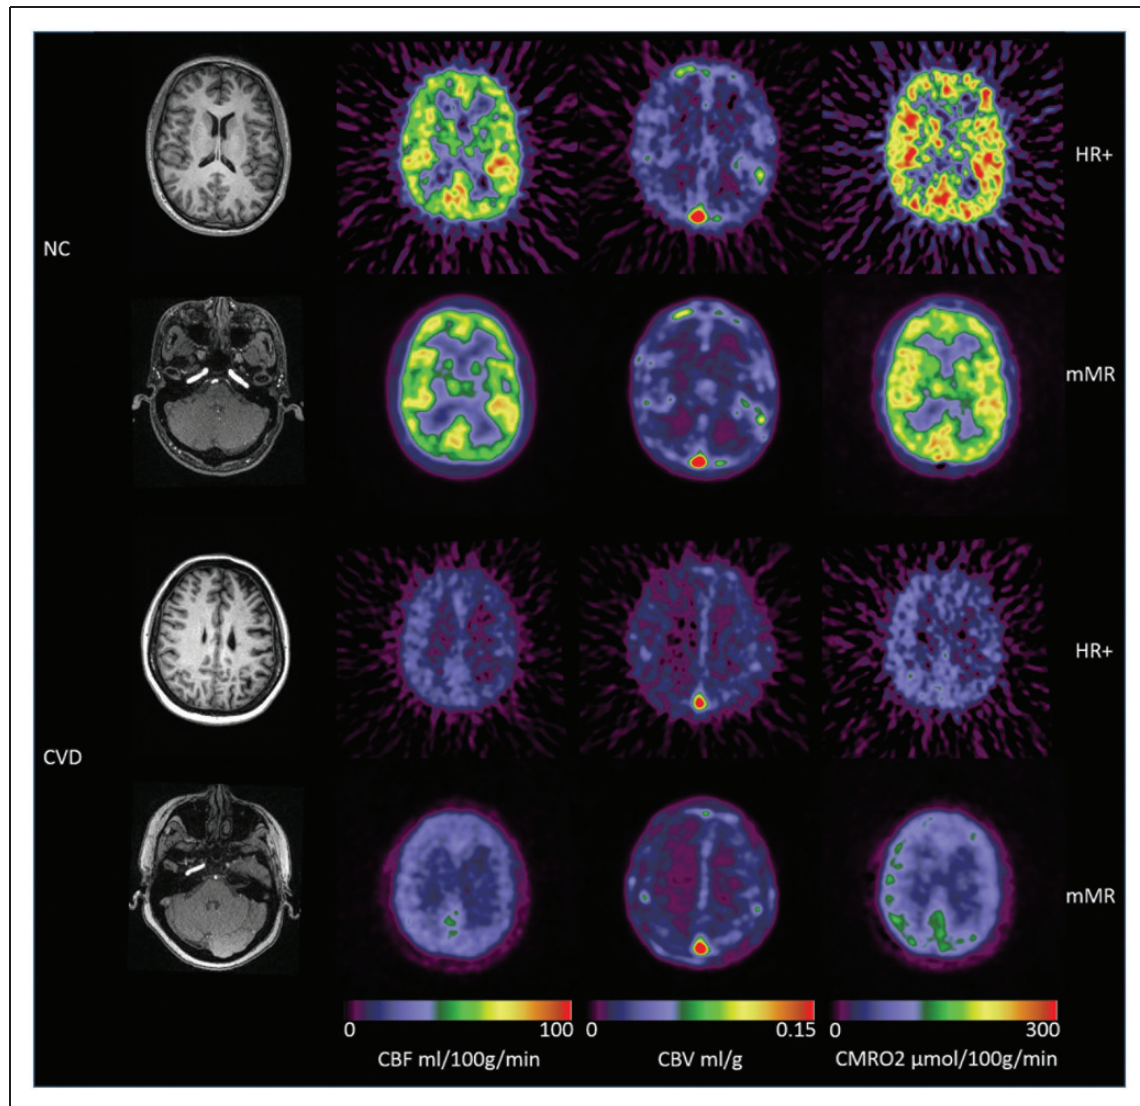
Example hemodynamic parametric images from a normal control (NC, #7) participants (top two rows) and a cerebral vascular disease patient (CVD, #11) (bottom two rows). Also included were the T1-weighted MR images and the TOF-MRA data at the level of internal carotid artery. It can be observed that the left internal carotid artery was occluded for the CVD patient, and in addition to the overall reduction in CBF and CMRO2, asymmetry can be observed in the CVD patient, whose left hemisphere had lower CBF and CMRO2, and higher CBV. The parametric images obtained on the mMR scanner had better signal to noise ratio.
